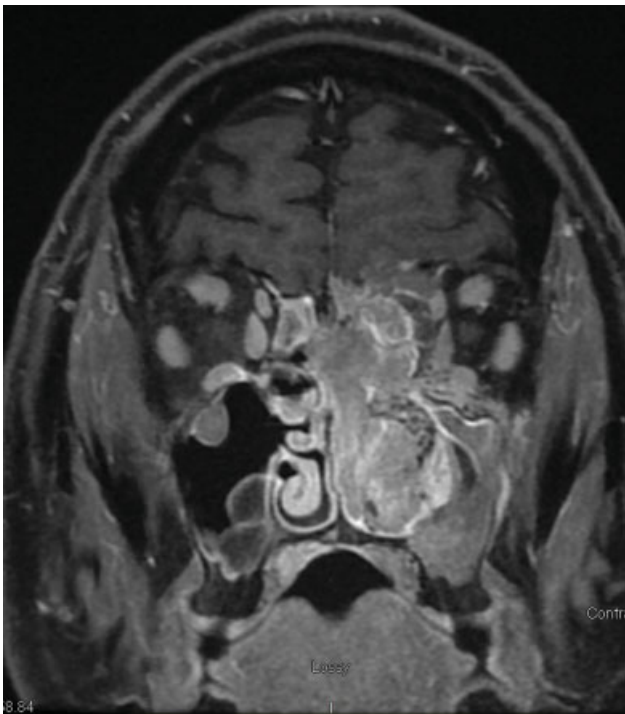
Preoperative MRI, coronal view.
